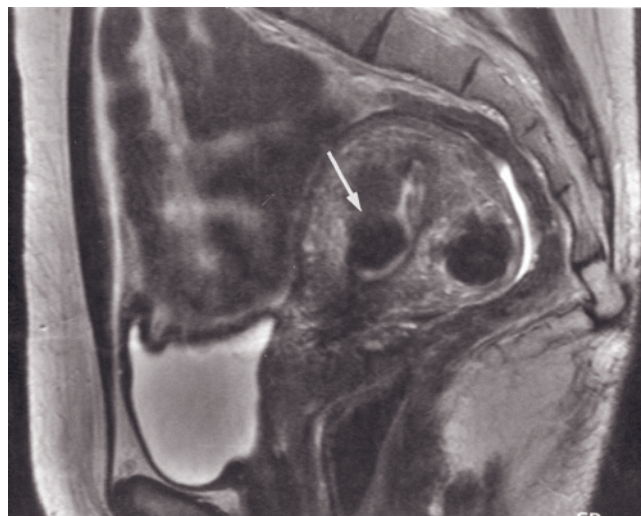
Subserosal leiomyoma. Sagittal T2-weighted ETSE image demonstrates a subserosal sharply margined, hypointense lesion with a hyperintense rim (arrow).
